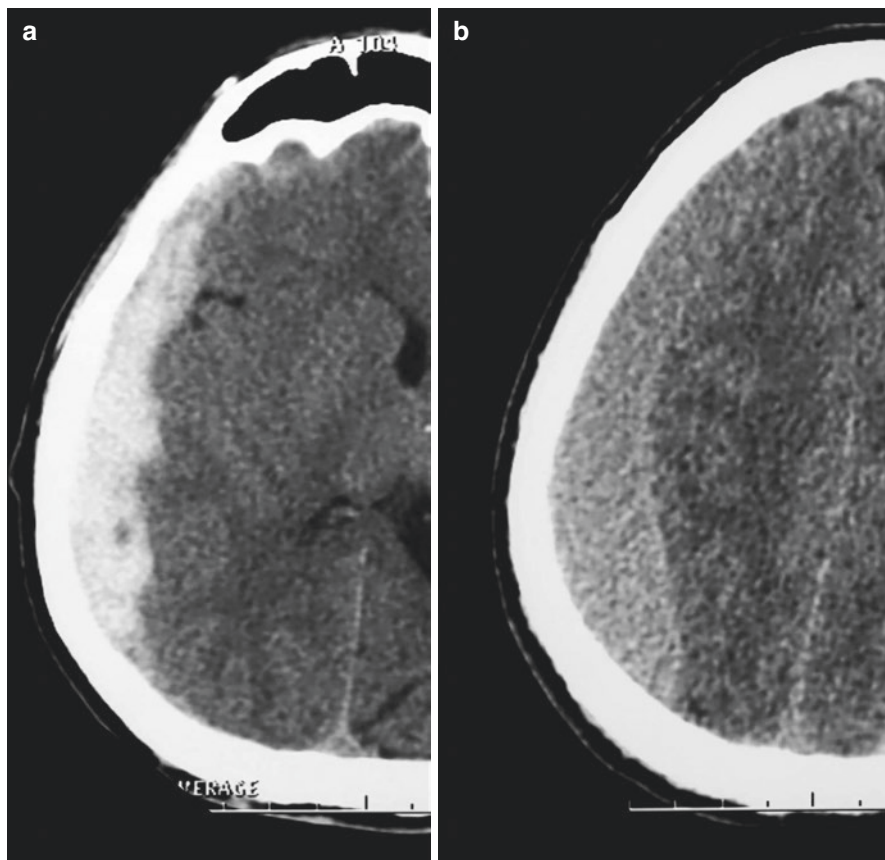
Computed tomography appearance of acute (a) and subacute (b) subdural hematomas
